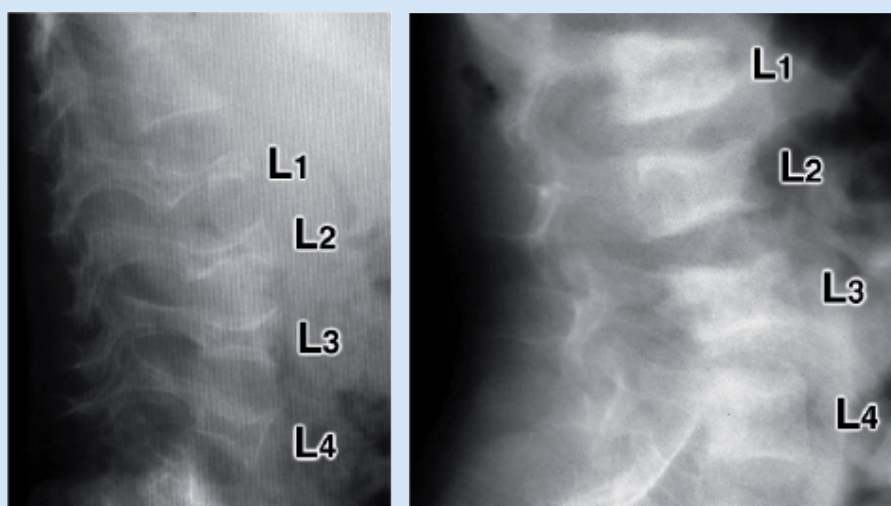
Lateral lumbar spine radiographs of two children of 3.3 years of age with osteogenesis imperfecta type III. The child in the left panel never received pamidronate, whereas the child in the right panel received 3 years of pamidronate therapy. Adapted with permission from [37].
